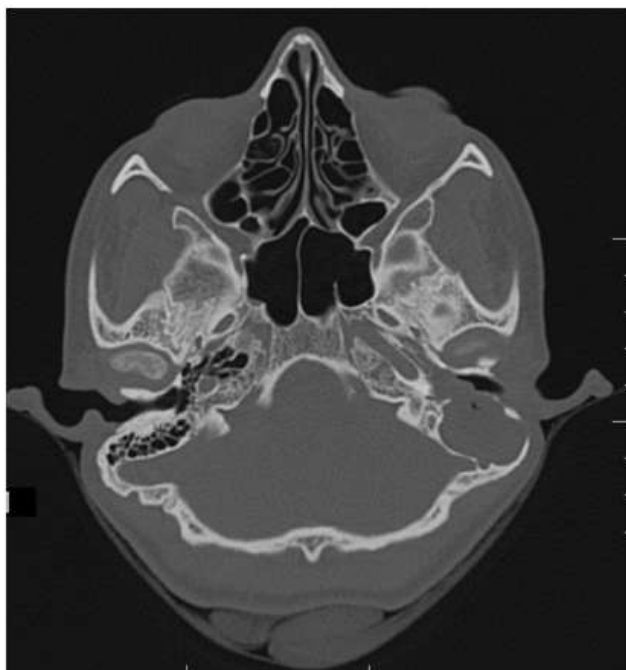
Axial view of CT Temporal Bone, demonstrating left Otitis Media
